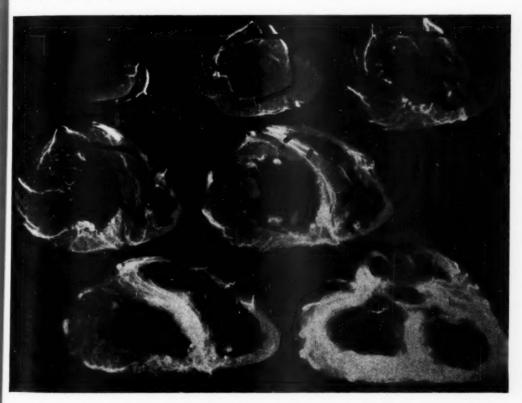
Roentgenogram of the injected heart in Case 69, showing small, healed anteroseptal infarct in broken outline and recent anteroposterior and septal infarct in solid lines.
